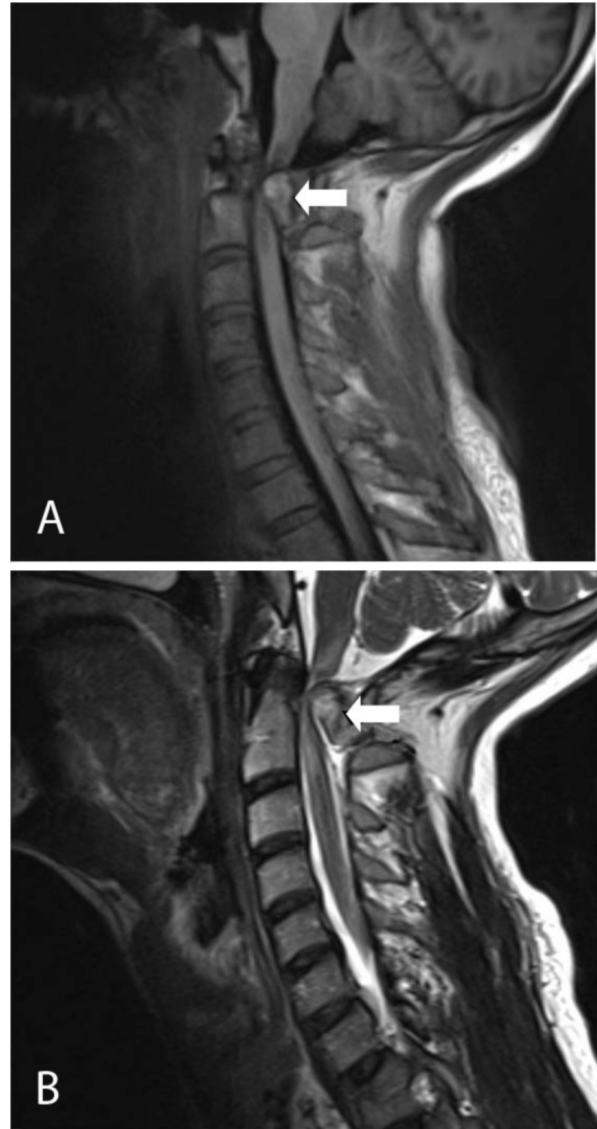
Sagittal STIR (A, TR 2000 and TE 22) and T2 (B, TR 4000 and TE 108) MR images of the cervical spine demonstrate osteochondroma (arrow) arising from the left C2 lamina and compressing the spinal cord. The lesion is continuous with the cortex and medullary cavity of the C2 lamina.
